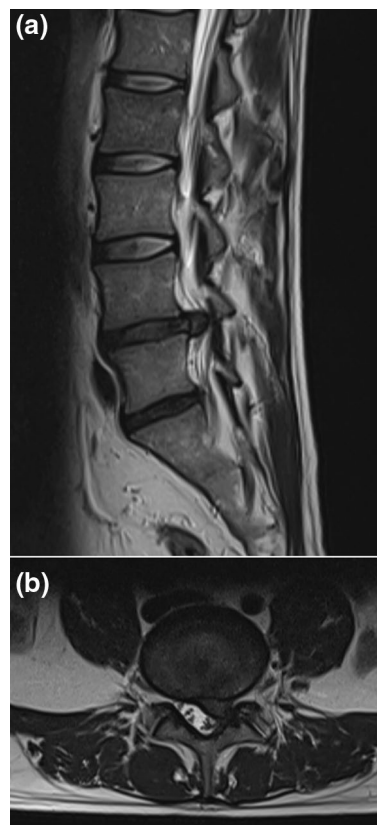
36-year-old male patient with a left L4–5 disc herniation with reserved disc height and no foraminal stenosis. a T2-weighted sagittal view; b T2-weighted axial view
